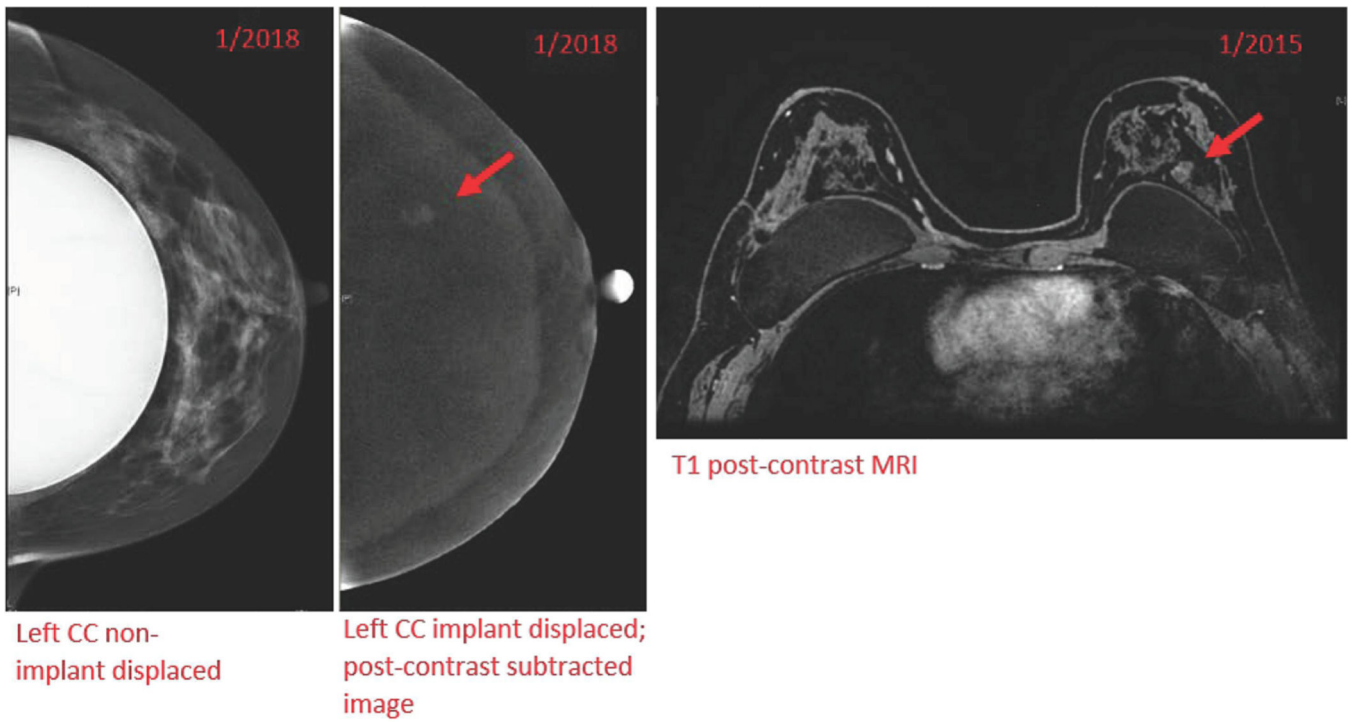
51-year-old woman in whom CEM was performed for high-risk screening. (A) A subpectoral silicone implant is in place. (B) Post-contrast implant displaced mammography demonstrates a circumscribed enhancing mass, correlating with (C) a stable benign mass on a prior MRI. The mass was assessed as BI-RADS 2.
